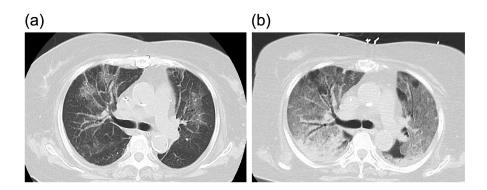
CT scan imaging of pneumocystis pneumonia development in patient with Cushing's disease after metyrapone initiation (a) Day 6 after initiation of metyrapone, (b) Day 11 after initiation of metyrapone.
